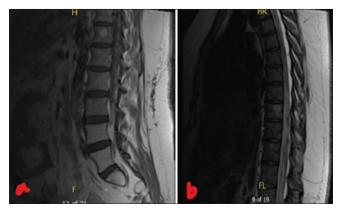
(a) Lumbar spine magnetic resonance imaging (MRI) T2 showing leptomeningeal enhancement along the conus and innumerable tiny nodular enhancing foci along the descending cauda equina nerve roots. (b) Thoracic spine MRI T2 with contrast showing diffuse leptomeningeal enhancement of the thoracic cord.
